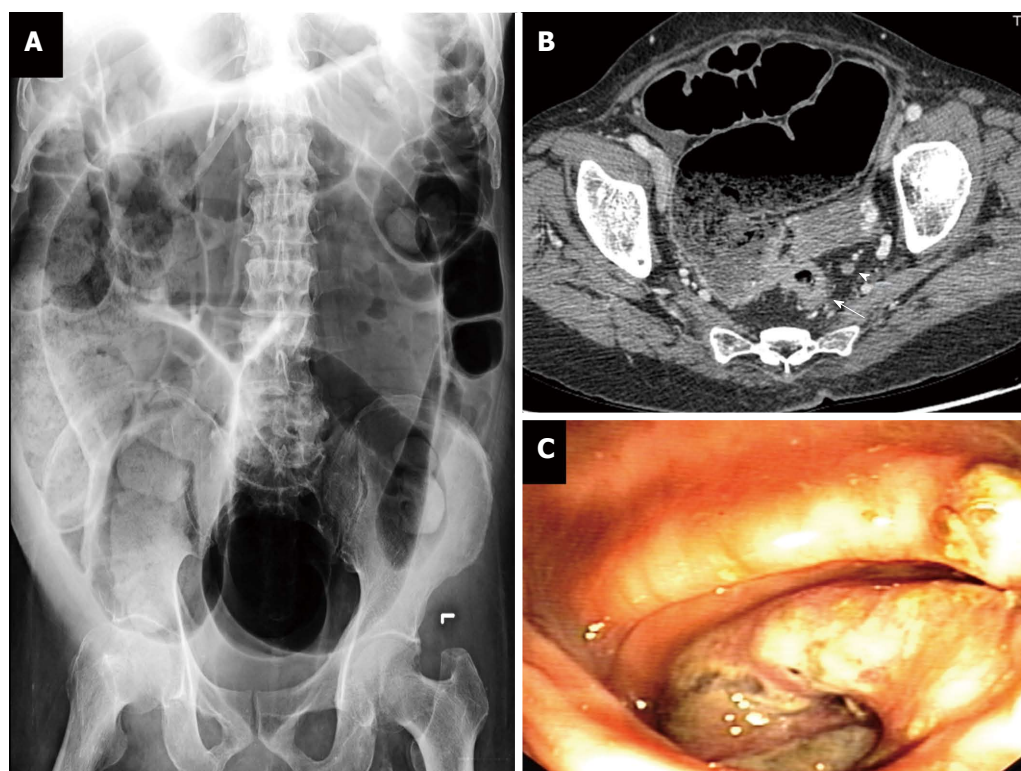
Obstructing rectal cancer: plain abdominal radiography (A), computerized tomography (B), and endoscopic view (C). T3 rectal cancer (white arrow) and perirectal lymph node (arrow head).
